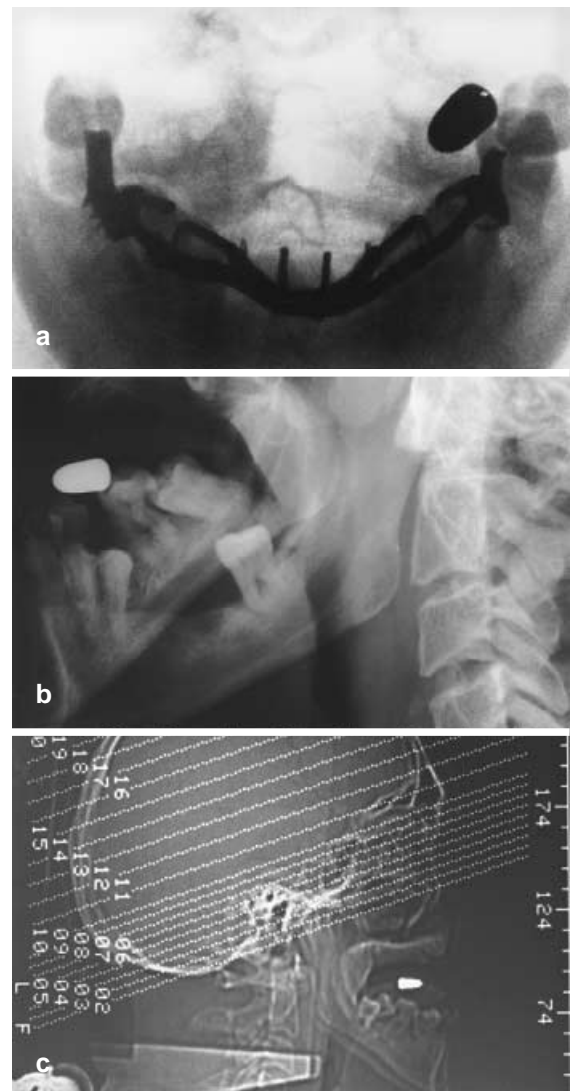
a First X-ray investigation showing the typical formed bullet near the dental bridgework into projection to the mouth. b X-ray and c CT 2 days after the first medical examination; the projectile is visible in both pictures
